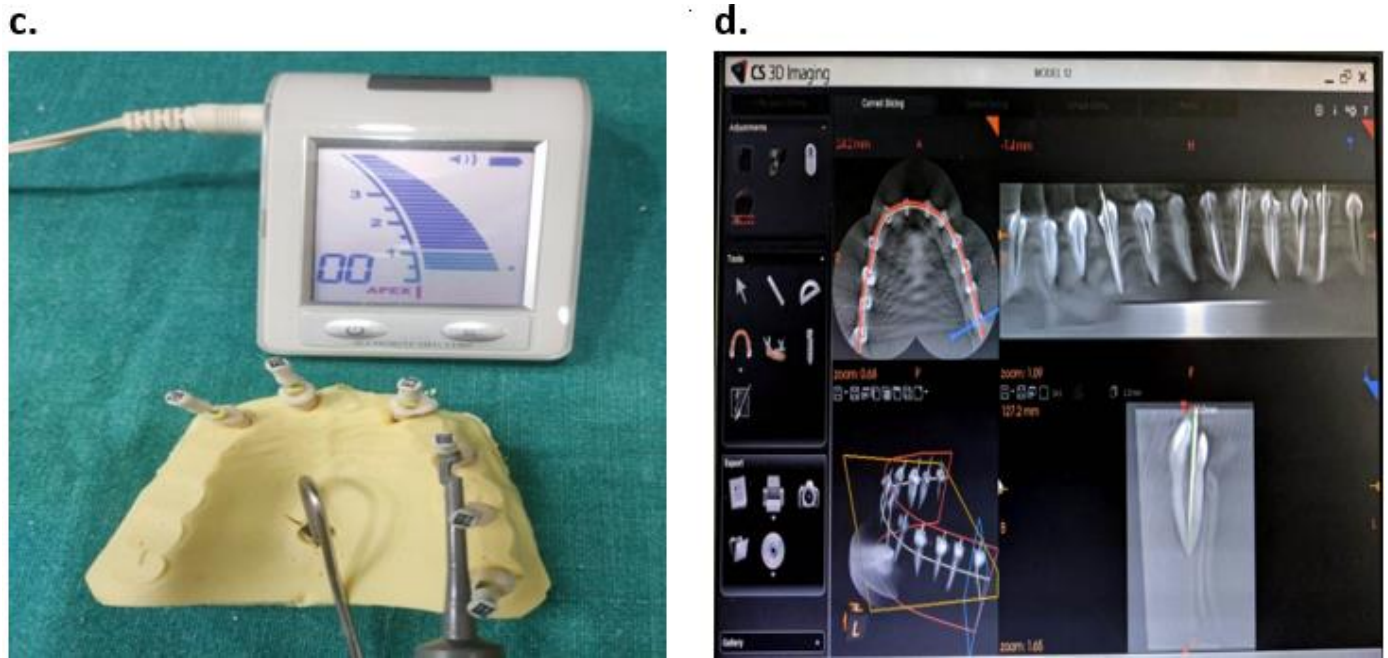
a. Manual method ,b. Using RVG (Sopro imaging 2.38 software) for WL ,c. Working length measurement using Root ZX mini Electronic Apex locator d. CBCT working length using CS 3D software
